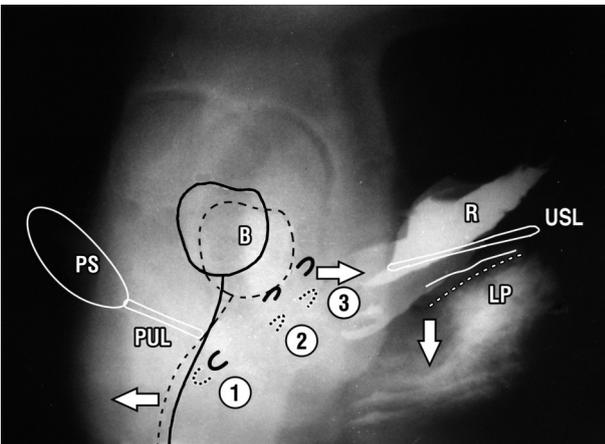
Same patient and labeling as figure 1. The 3 directional movements which close the urethra during effort. Standing lateral xray, the squeezing film (broken lines) is superimposed on the resting film (unbroken lines). Vascular clips have been applied to the anterior vaginal wall: ‘1’ to midurethra; ‘2’ to bladder neck; ‘3’ to bladder base. The unbroken lines represent the resting position and the broken lines the straining or coughing position. Reflex muscle movements stretch the distal urethra ‘1’ forwards and downwards around the pubourethral ligament ‘PUL’ to close it. The bladder neck ‘2’ and bladder base ‘3’, are stretched backwards against PUL by LP and downwards by the downward angulation of levator plate ‘LP’, (downward arrow). This action closes proximal urethra and bladder neck. The downward forces (arrow) pull against the uterosacral ligaments (USL).
